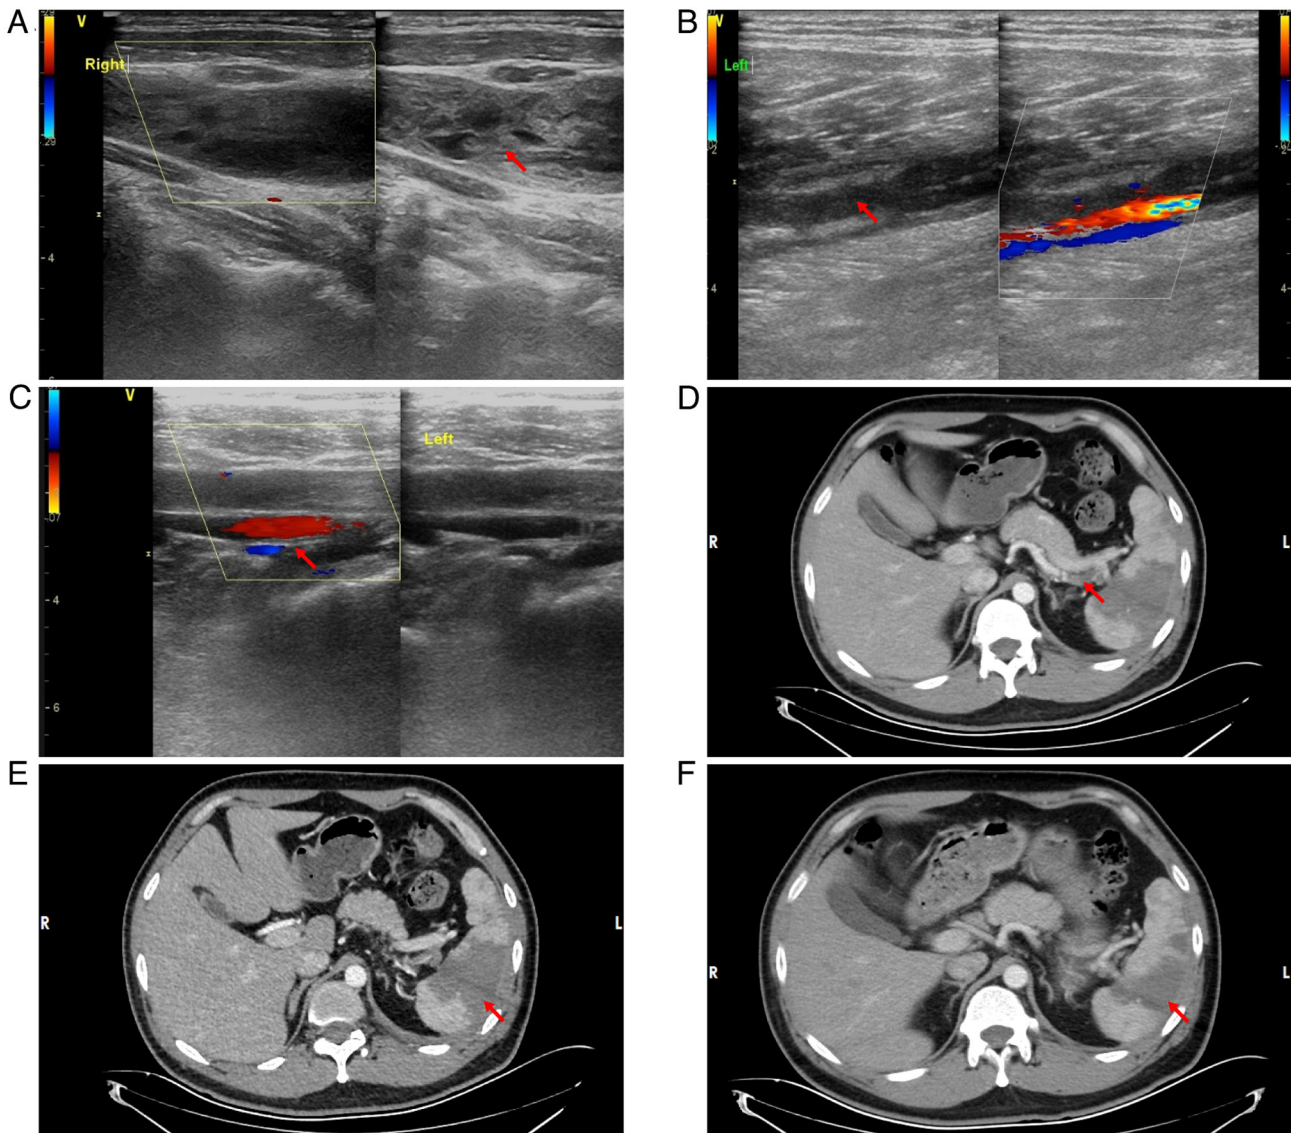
Ultrasound findings indicating multiple thrombi formation in multiple locations and contrast-enhanced abdominal CT revealing splenic infarction. A colored scale is used to indicate the direction and relative velocity of the blood flow signal, with red indicating blood flow towards the ultrasound probe and blue indicating blood flow away from the ultrasound probe. (A) Color Doppler ultrasound indicated thrombosis in the right internal jugular vein. The red arrow indicates a thrombosis. (B) Color Doppler ultrasound demonstrated thrombosis in the left popliteal vein. The red arrow indicates a thrombosis. (C) Color Doppler ultrasound indicated thrombosis in the left peroneal vein. The red arrow indicates a thrombosis. (D) Contrast-enhanced abdominal CT demonstrated splenic artery thrombosis and the red arrow indicates the thrombus. (E) Contrast-enhanced CT demonstrated wedge-shaped hypodensity in the splenic parenchyma, indicated by the red arrow, consistent with ischemic infarction. No evidence of liquefactive necrosis or abscess formation was observed. (F) Following a standard anticoagulation regimen (8,000 IU subcutaneously every 12 h), at 1 month post-treatment, contrast-enhanced CT revealed a slight reduction in the extent of the splenic infarction. The red arrow indicates the infarcted spleen.
